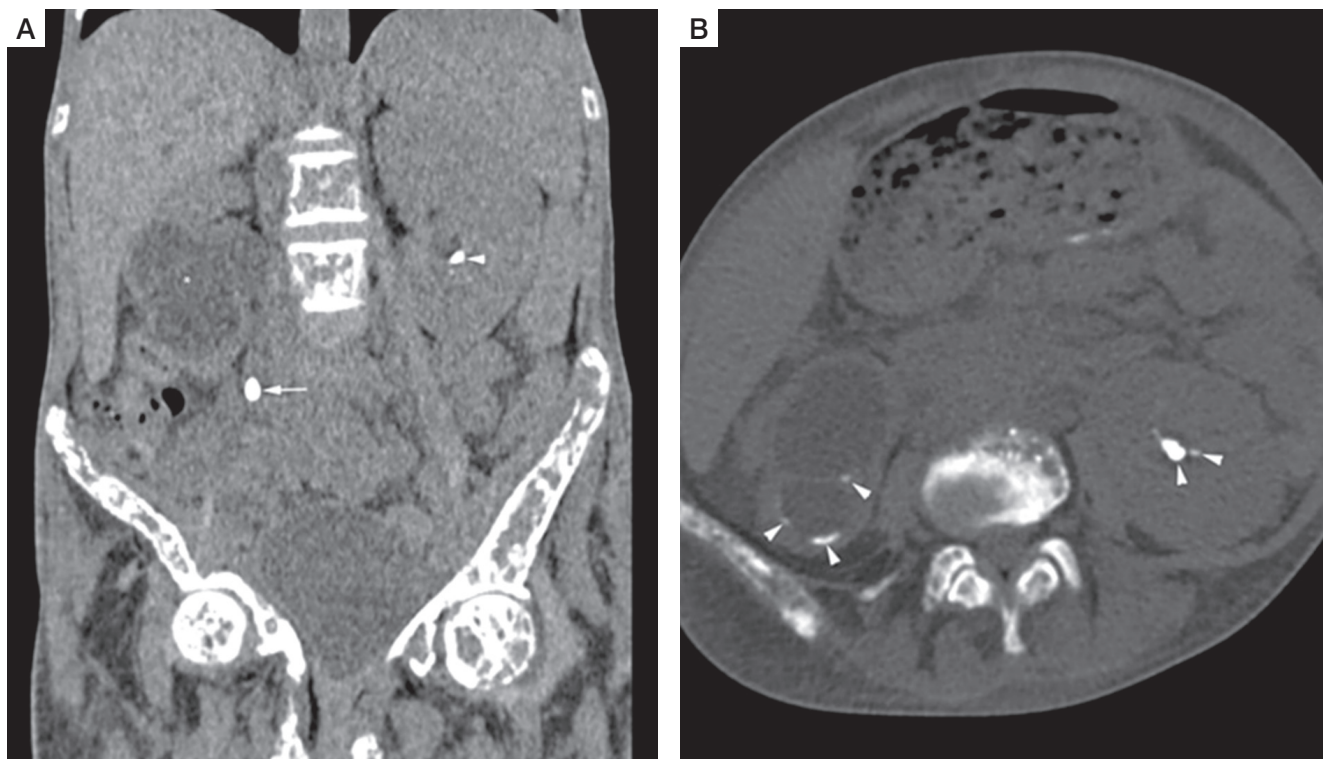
Non contrast computed tomography (NCCT) of kidney, ureter, and urinary bladder (KUB). Coronal (A), and axial (B) NCCT KUB images shows right ureter calculus (white arrow) causing right hydroureteronephrosis (white asterisk), and bilateral renal calculi (white arrowheads)
